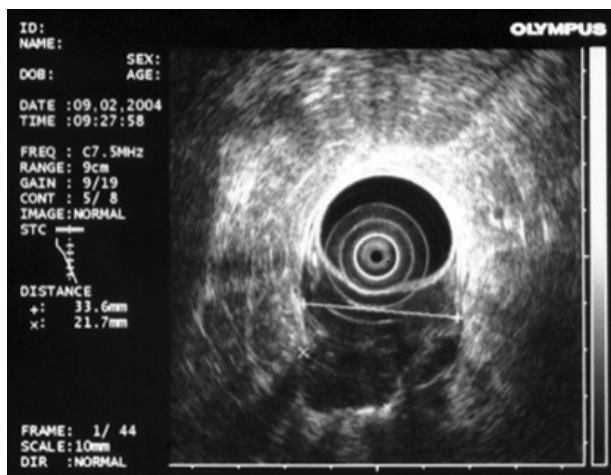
Endoscopic ultrasonography shows a tumor measuring 3x4 cm in the descending duodenal portion that spreads throughout the duodenal wall and enlarged regional lymph nodes.
